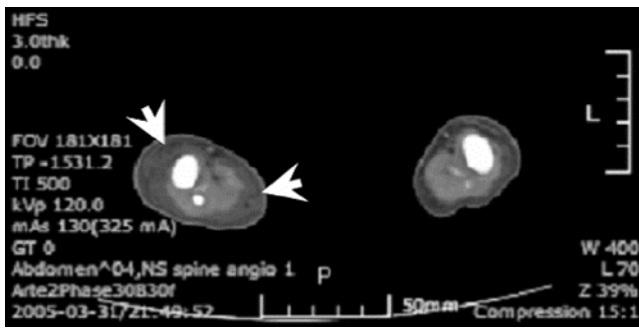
Thigh CT shows lymphedema (arrows) of the right lower extremity.
